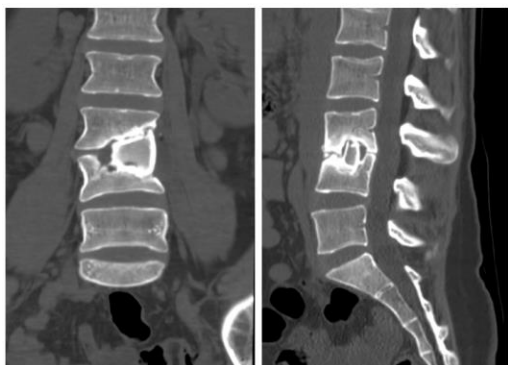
Tuberculous spondylitis L3-4: CT scan of the lumbar spine, coronary and sagittal projection (a block was formed from the remnants of L3-4 bodies, without fresh destructive changes; soft tissues are densified in the paravertebral region, there are no abscesses)
